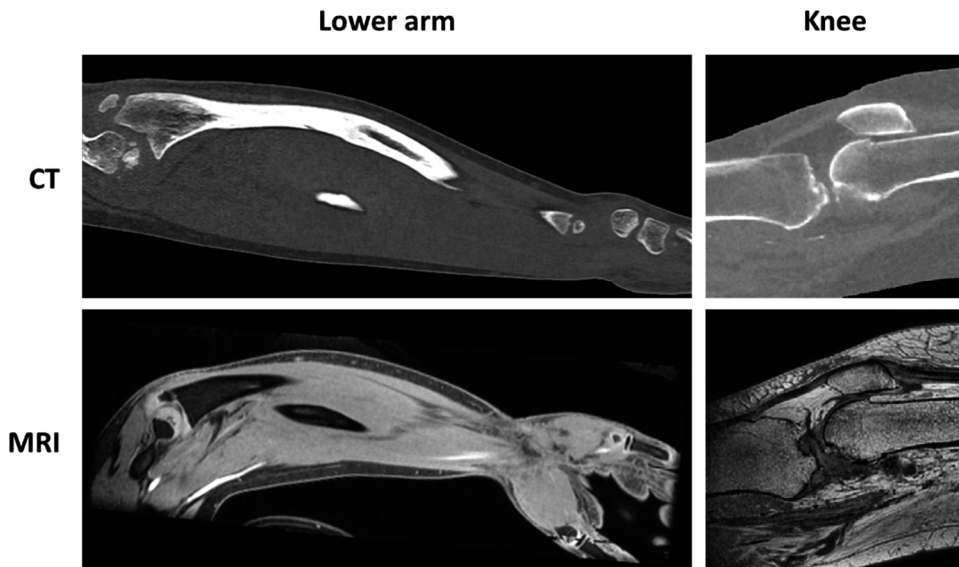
Comparison of CT and MRI for the imaging of the lower arm and knee. Each image shows a single slice of a larger 3D scanned volume. Note that the MRI scans have different contrasts.
